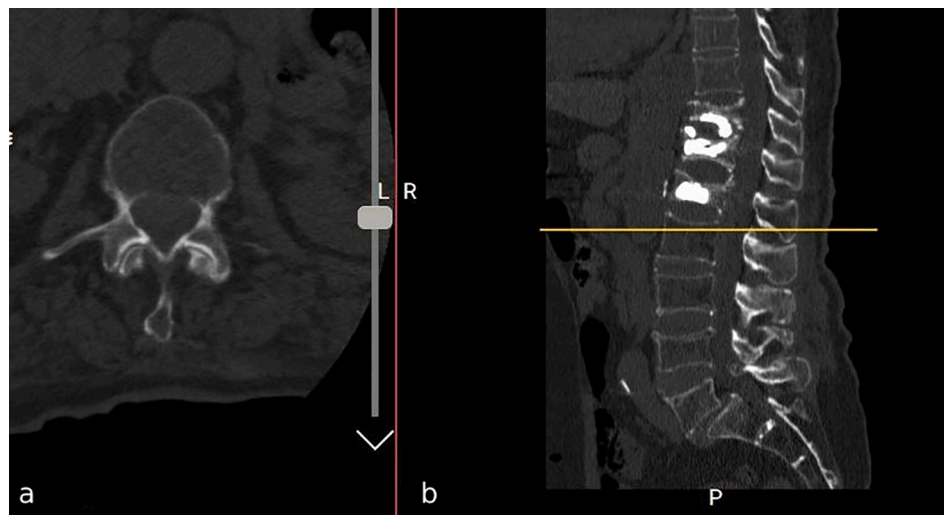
Resolved epidural hematoma after three months in axial (a) and sagittal (b) CT scan.
